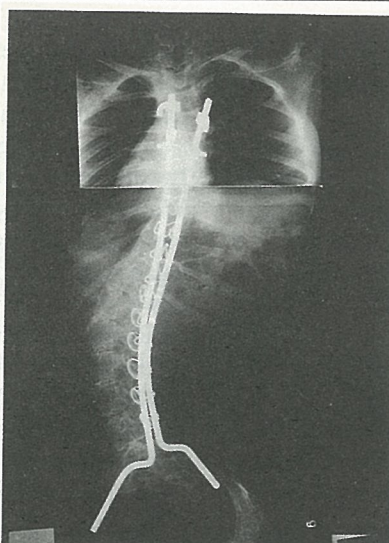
X-ray of the same patient after anterior release and posterior Luque-Galvestone operation.
